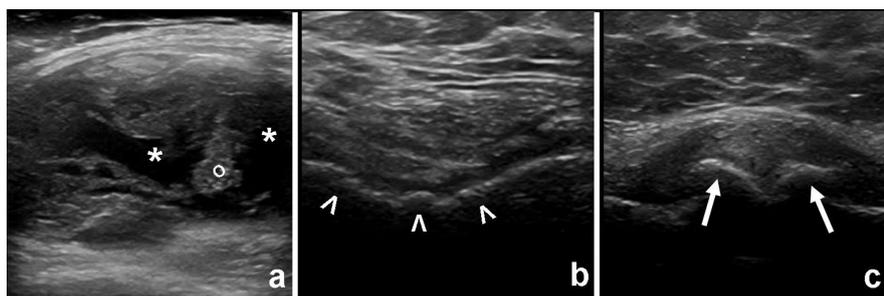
Grey-scale sonographic findings in knee osteoarthritis. (a) Anterior para-patellar longitudinal scan showing the presence of local effusion (*) and synovial proliferation (o). (b) Anterior supra-patellar transverse scan showing the femoral hyaline cartilage (arrowhead) abnormalities with evidence of loss of cartilage anechoic echostructure, loss of margins sharpness, irregularities of margins and thinning of the layer. (c) Longitudinal scan at the level of the medial aspect of the knee joint showing the presence of large osteophytes (arrows) visualised both proximal (femoral side) and distal (tibial side) to the joint.
